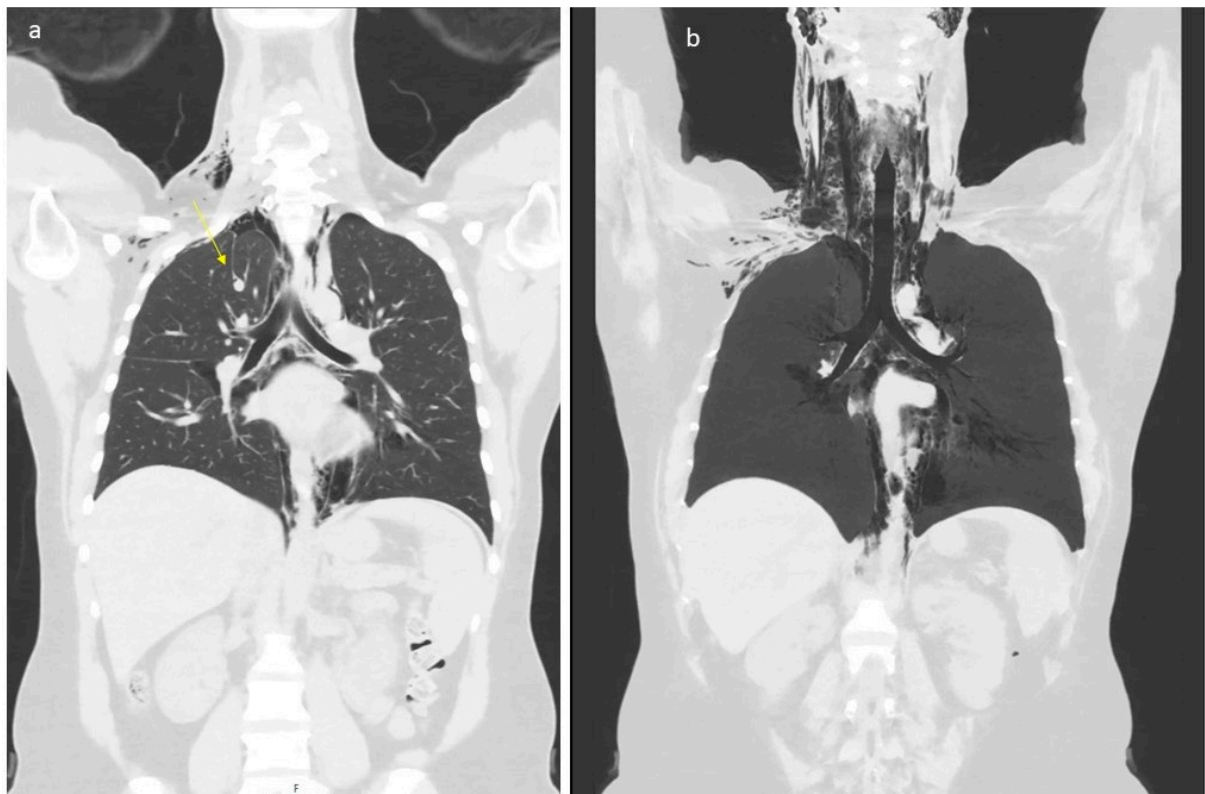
Low dose CT scan showing air within the mediastinum starting caudally in the level of hiatus aorticus, surrounding the pericardium, throughout the mediastinum. In the neck level, air was seen subcutaneously (part A), along the great vessels (carotid space) and in the retropharyngeal space (part B). The patient has an «azygos lobe», a normal variant with the vena azygos running laterally with a pleural fissure surrounding it (arrow, part A). Air bubbles can be seen along the vein and small amounts of air within the pleural cavity apically on the right side. Apart from this, no signs of pneumothorax. Small amounts of pleural effusion is seen bilaterally. The upper abdomen was included in the low-dose scan, without any signs of air below the diaphragm.
